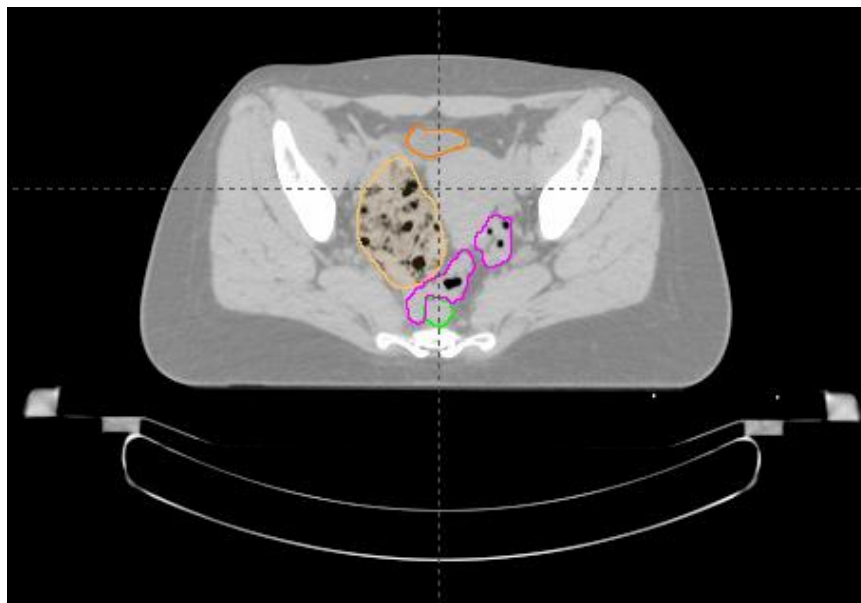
Axial CT image of a patient with a gynecological tumor, in which several anatomically relevant structures for RT planning are delineated.
